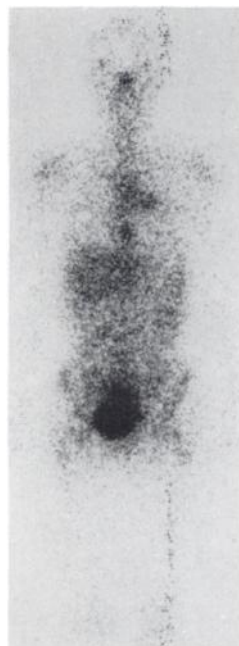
Chest roentgenogram (A) demonstrates right mastectomy and chronic radiation changes in right upper lung. Gallium scan (B) shows intense mediastinal uptake. Following positive biopsy for metastatic breast carcinoma and subsequent chemotherapy, gallium scan is normal (C).
